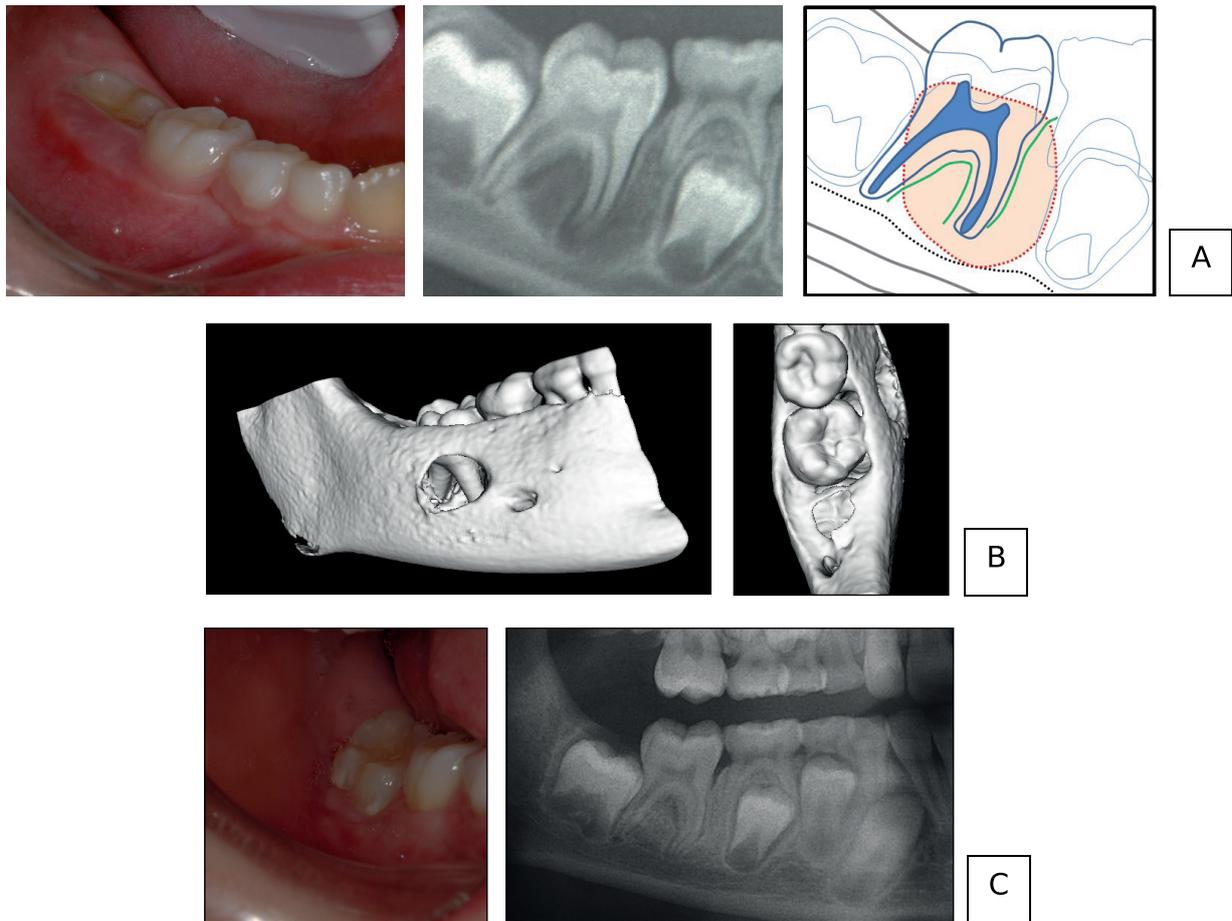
Case 2. A: initial situation, partial eruption of 46, associated to a radiolucency lesion on panoramic x-ray. B: 3D reconstructions showing a fenestration of the external cortical, associated to the buccal tilting of the crown. C: intraoral view, 2 months after surgical management, showing eruption of the lower right first molar and panoramic radiograph, 3 months later, demonstrating a full healing of bone.
